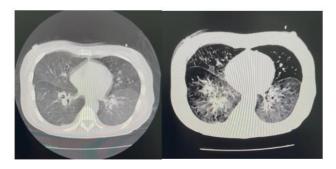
Thoracic CT scan with presence of bilateral ground glass infiltrates
